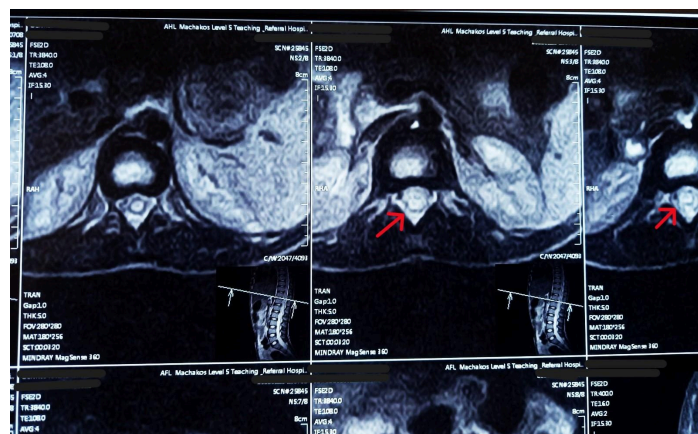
An axial lumbar MRI showing an intramedullary intradural syrinx
